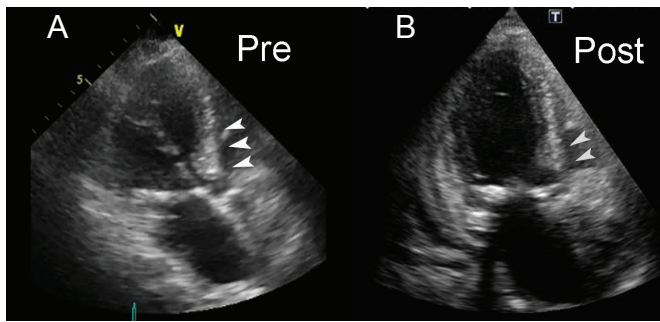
Preoperative and postoperative echocardiogram. Preoperative echocardiogram showing severe aortic valve stenosis and septal LV hypertrophy (A, white arrow). Postoperative echocardiogram demonstrating a reduction in hypertrophic myocardium and a widely patent LV outflow tract (B, gray arrow).
